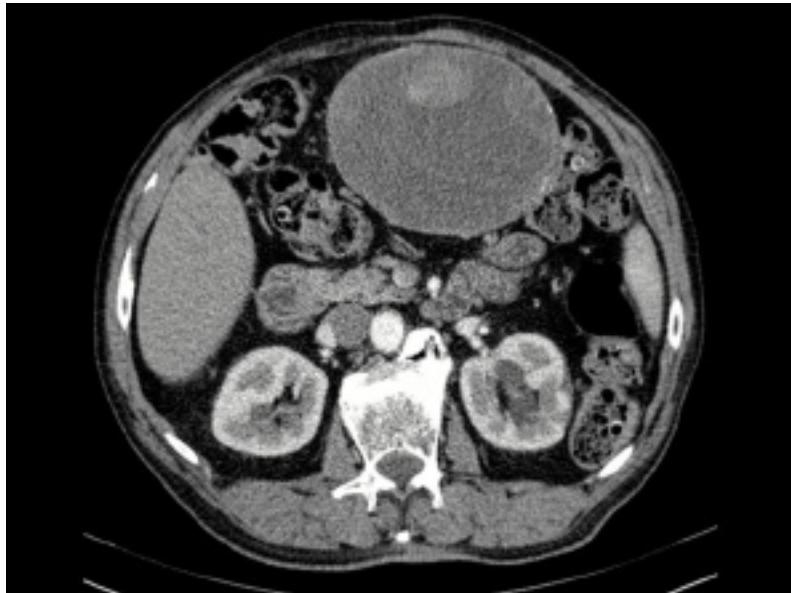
CT scan showing abdominal mass.
